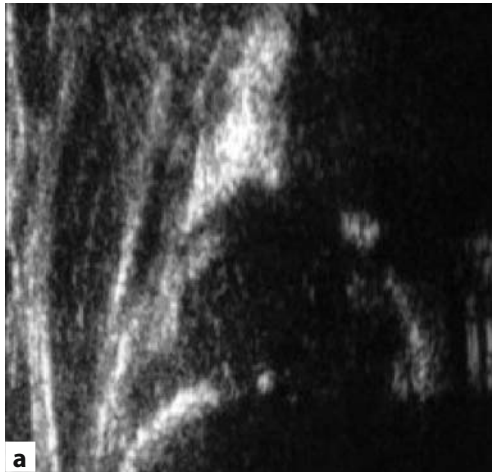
a Four months, right hip. Please do not forget to check for tilting error. This sonogram is not usable. Tilting error (ventral – dorsal). b *l*, Blurred and oblique os ilium
